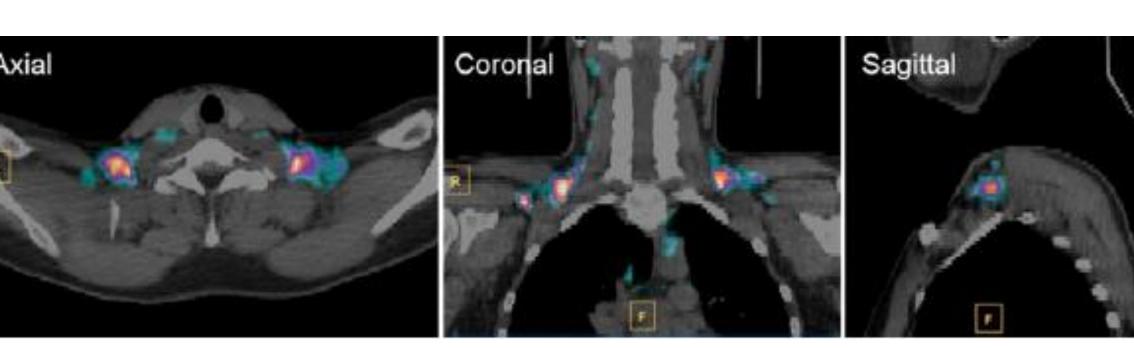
Metabolically active BAT from neck to axillary regions identified by FDG uptake on PET/CT images.
